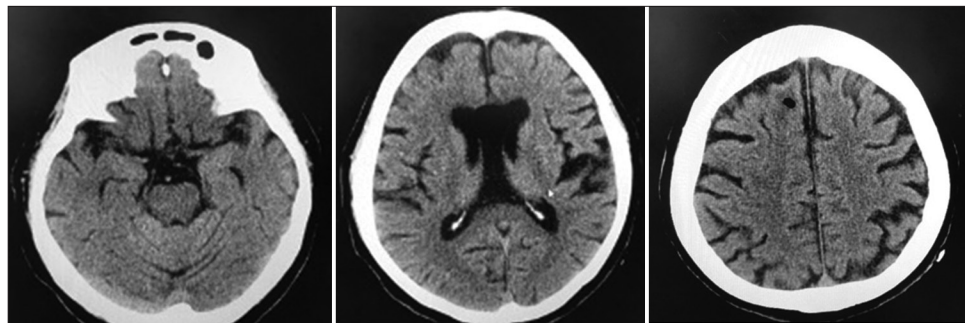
Head CT just after the operation. There are no visible signs of hemorrhage, infarction, or cerebral herniation.
